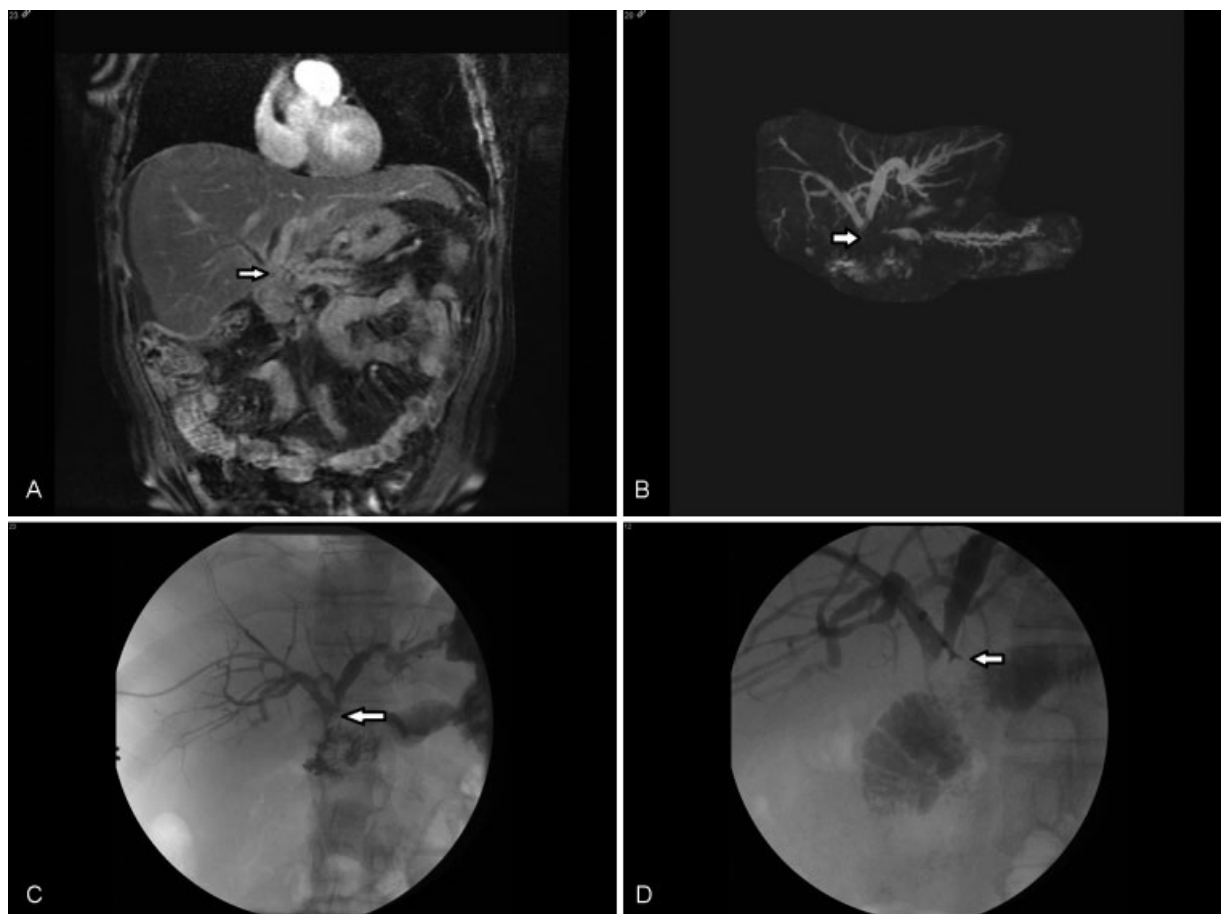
A 74-year-old woman presents with recurrent cholangitis. (A) Coronal gadolinium-enhanced T1-weighted fat-saturated image demonstrates ill-defined stricture at the level of the hilum (arrow) with intrahepatic ductal dilatation. (B) Coronal T2-weighted MR cholangiopancreatography image demonstrates abrupt cutoff of both right and left intrahepatic ducts (arrow). (C) Percutaneous transhepatic cholangiography demonstrates severe narrowing of the common bile duct (arrow). (D) Biopsies were taken using a forceps device (arrow). MR, magnetic resonance.
